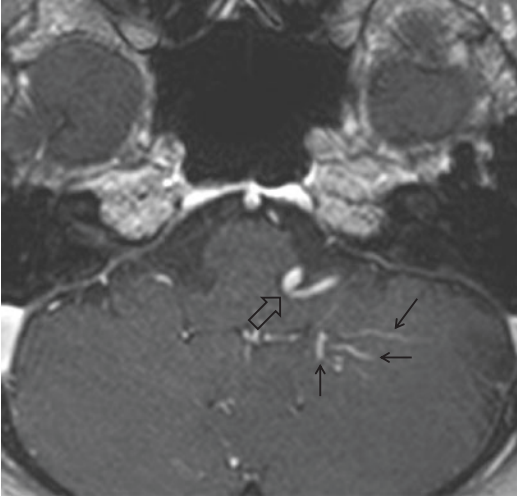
Hemifacial spasm caused by developmental venous anomaly. 3D axial contrast-enhanced bTFE MRI shows multiple small collecting veins (arrows) in the left cerebellum that drain into a single dilated transcortical vein (open arrow) at the root exit zone of the facial nerve, characteristic of developmental venous anomaly
